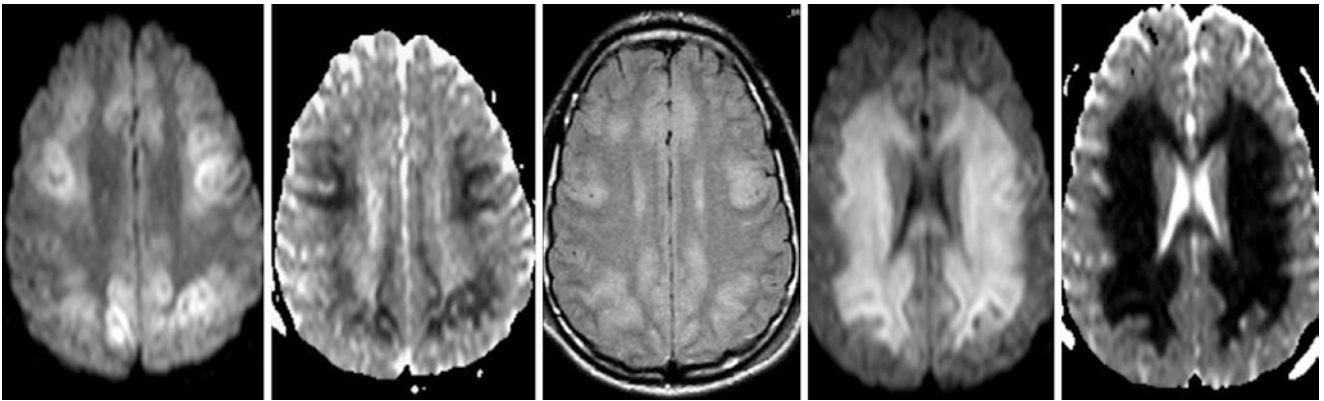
Comparison case of HIE. In a 13-year-old, a 3 T MRI obtained 5 days after cardiac arrest from drowning showed multifocal hyperintense cortices on DWI (*left*), with corresponding dark signal on ADC maps (*left middle*), and with hyperintensity on FLAIR (*middle*).
